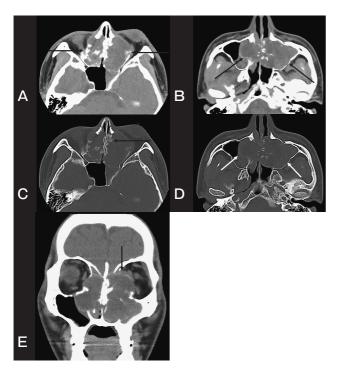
Axial (A–D) and coronal (E) computed tomography images with soft-tissue and bone windows. A $6\times5\times4$ -cm soft-density tumor with distinct and relatively irregular margins centered on the nasal cavity was observed (black arrows in A,B). Destructive invasiveness of the nasal septum (black arrow in C) and other surrounding bone and crescent-shaped bone remodeling at the tumor margins (white arrows in D) were observed. Progression into the bilateral maxillary sinuses, orbits, and ethmoid sinuses was observed, along with severe displacement of the left orbital structures (black arrow in E). Internally, fine calcification was observed.
